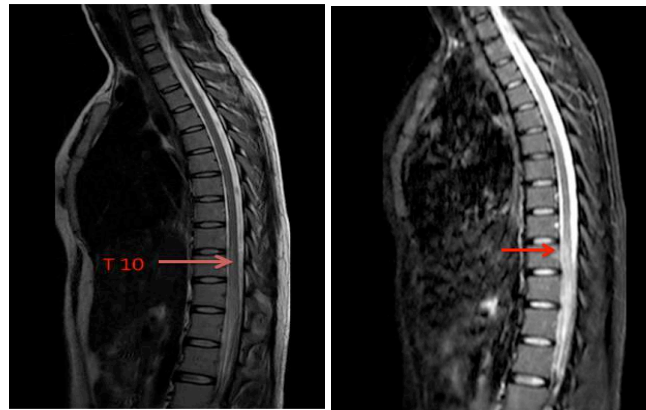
MRI Spine showing Hyperintensity with cord expansion T10 to conus (a: T2 Image; b: STIR Image)
